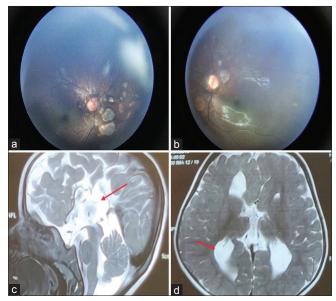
Fundus examination showing anomalous disc with peripapillary atrophy and chorioretinal lacunae around the disc in OD (a) and OS (b). T2-weighted MRI brain images: Sagittal view (c) showing agenesis of corpus callousum, axial view (d) showing widely spaced frontal horns with dilated trigones of lateral ventricles/colpocephaly-racing car sign (arrow)
